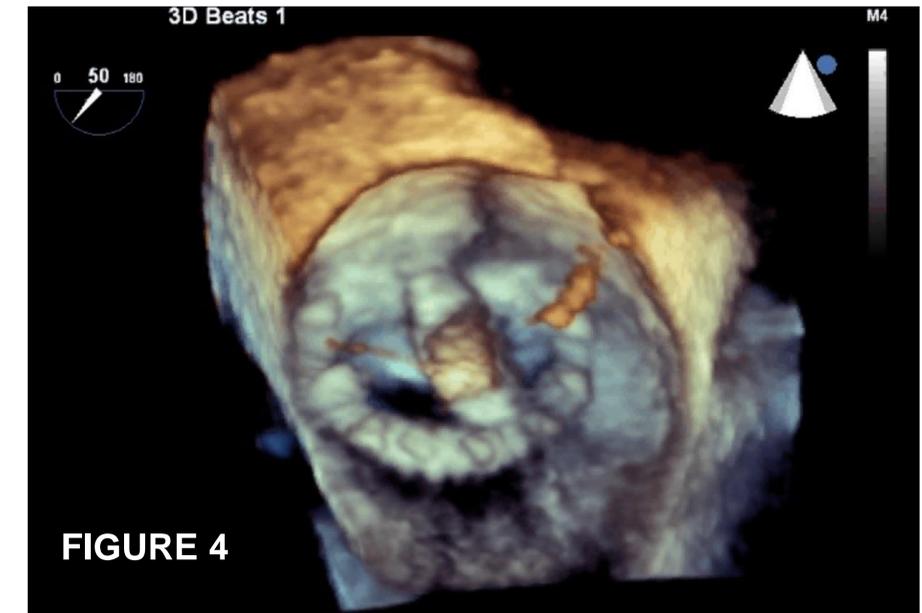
Pre-Clip 3D TEE images from left atrium with and without color Doppler demonstrating zone of annular dehiscence and peri-annular MR.
